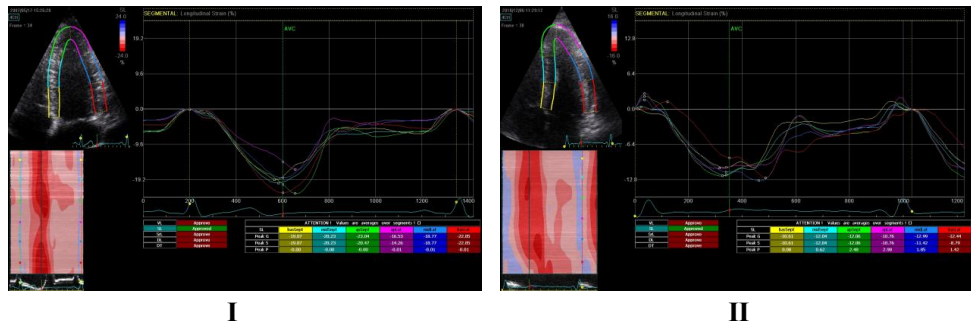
Typical example of regional LV myocardial deformation by speckle strain echocardiography from apical 4-chamber view. The analyses provide time curves of normal LV regional longitudinal strain in a healthy subject (panel I) and reduced strain, in an asymptomatic Fabry patient (panel II). Colour coding in Figure tables reflect the respective LV segments.
